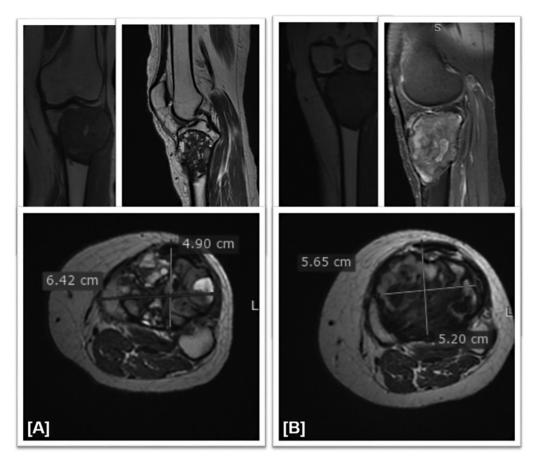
Representative image magnetic resonance imaging (MRI) of patient with giant cell tumor (GCT) in the proximal tibia. (A) Pretherapy and (B) posttherapy, where the longest diameter in the axial view used to compare the reduction in % of the size and increase in % of density.
